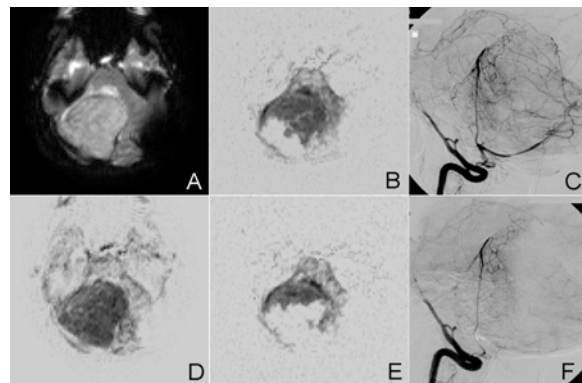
Baseline DCS image (A) of a meningioma along with difference images showing peak attenuation following IV (D) and IA (B-pre embo; D-post embo) Gd injection. X-ray angiograms obtained via the same vessel prior to (C) and following (F) embolization reveal partial devascularization.
